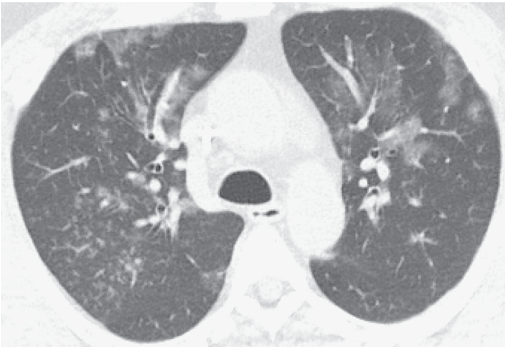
Cheat CT showing multifocal areas of ground-glass opacity.
